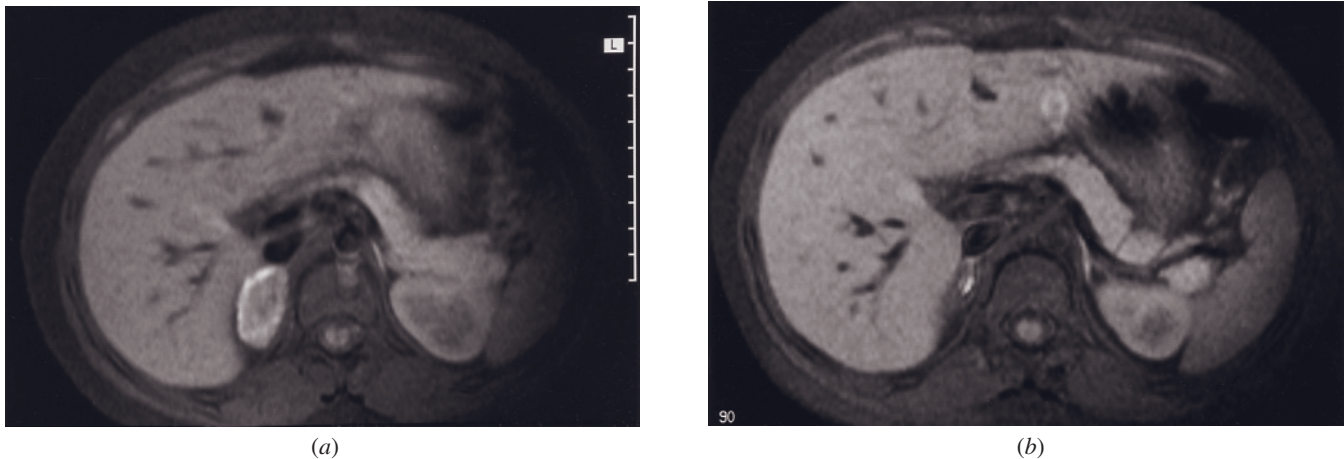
Adrenal hemorrhage. T1-weighted fat-suppressed spin-echo image (*a*) and T1-weighted fat-suppressed spin-echo image obtained 7 weeks later (*b*). The T1-weighted fat-suppressed image acquired 1 week after abdominal trauma (*a*) demonstrates a right adrenal mass with a hyperintense peripheral rim. This appearance is classic for a subacute hematoma. Seven weeks later, the mass has diminished in size and remains high in signal intensity because of persistence of extracellular methemoglobin (*b*).
